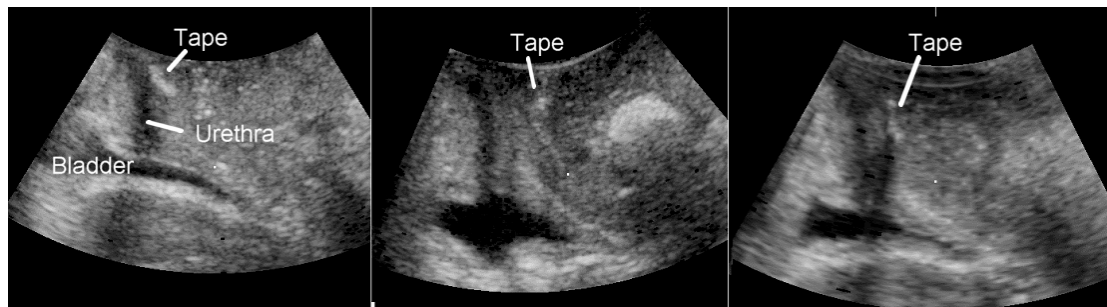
Midsagittal 2D translabial ultrasound of TVT, IVS and Sparc (from left to right).
